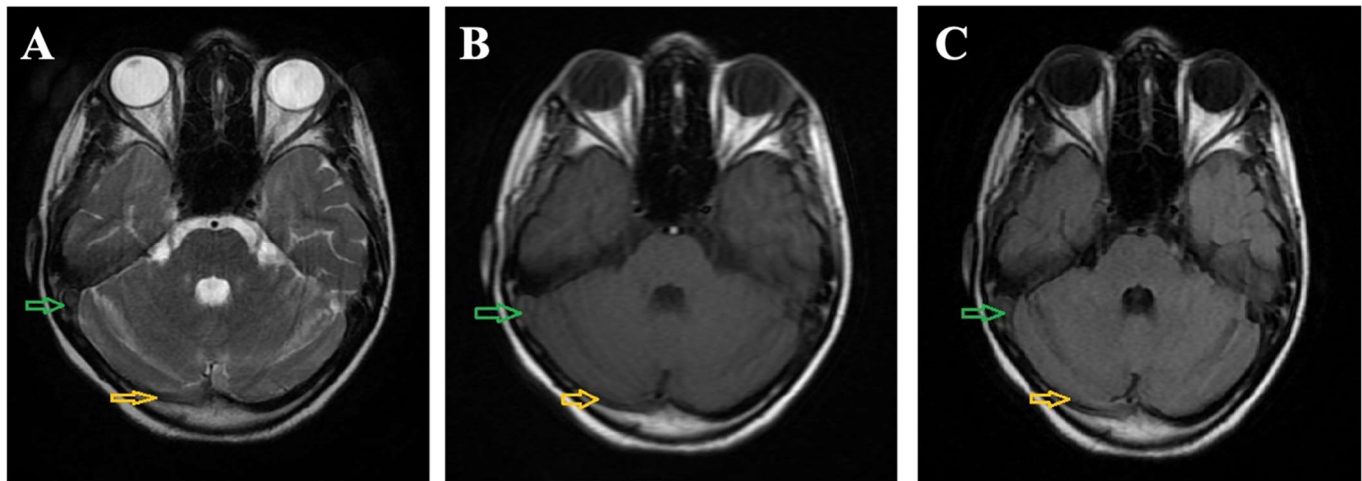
A) T2WI, B) T1WI Axial, C) FLAIR images showing right transverse and sigmoid sinus thrombosis.
